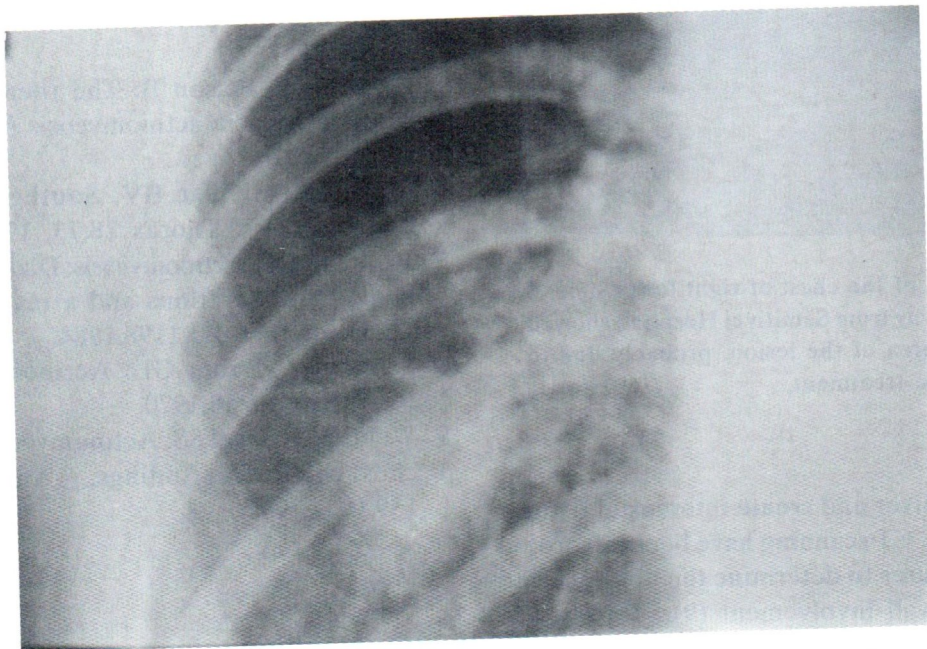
Plain film of the chest at right lower lobe, 7 days post Penicillin treatment, showed partial clearing at the superior part of the lesion.
